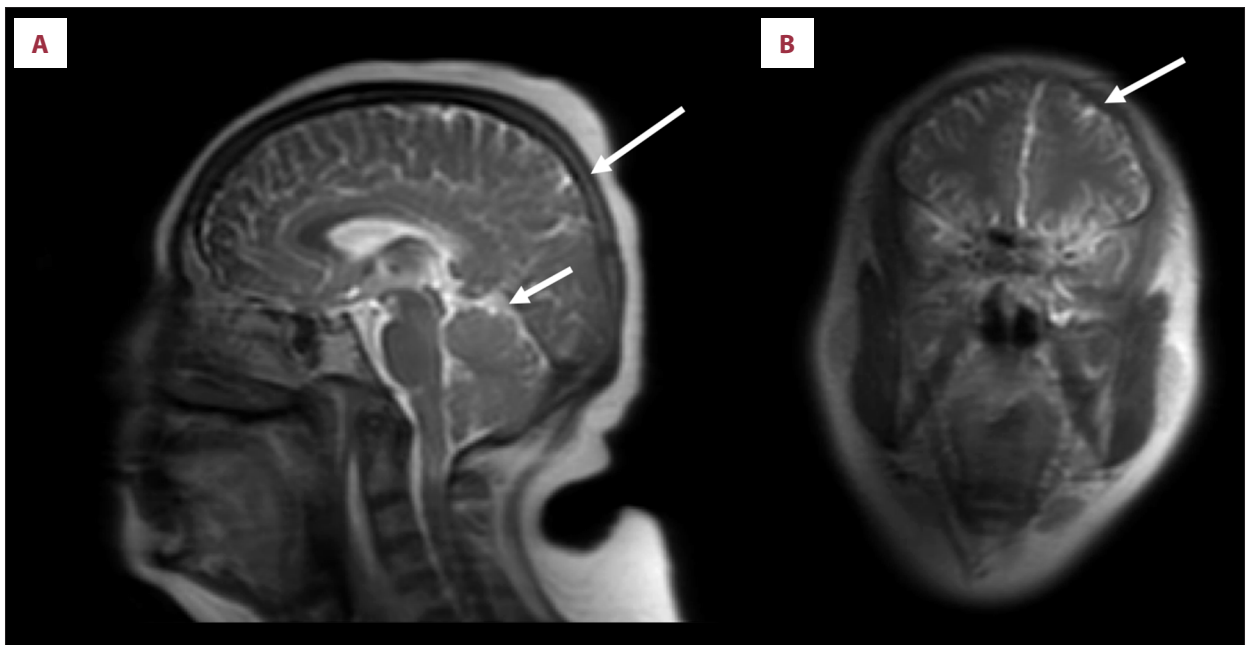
Magnetic resonance imaging of the head 23 months after the first visit (A: Midline plane; B: Coronal plane). The arrows point to metastatic lesions.
